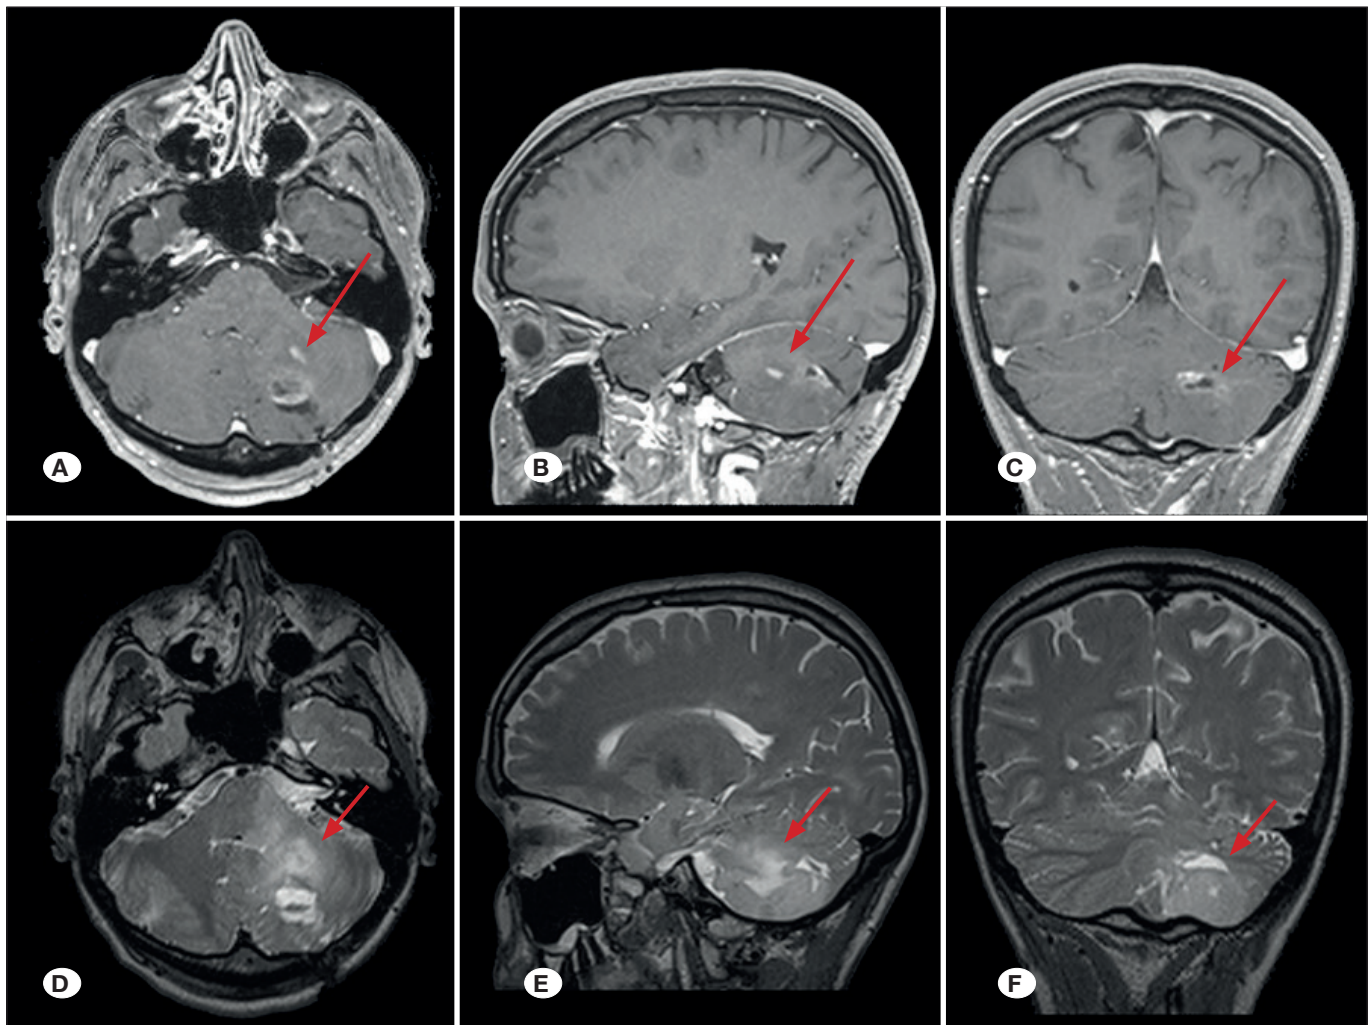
Preoperative gadolinium-enhanced MRI scans showing two lesions in the left cerebellar hemisphere that are approximately 1–1.5 cm in diameter. T2-weighted MRI sequences reveal concomitant edema. A) Contrast-enhanced axial section. B) Contrast-enhanced sagittal section. C) Contrast-enhanced coronal section. D) T2-weighted axial segment. E) T2-weighted sagittal section. F) T2-weighted coronal section. MRI: Magnetic resonance imaging.
